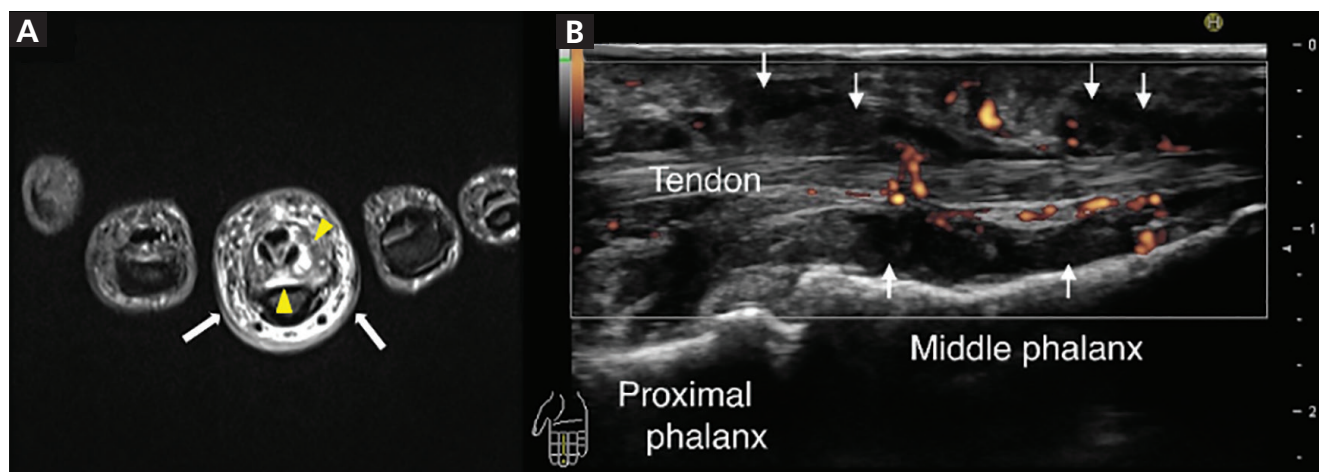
(A) Axial magnetic resonance imaging set on short time inversion recovery showed a high signal around the digital flexor tendon of the right middle finger (yellow arrowheads) and in the subcutaneous tissue (white arrows). (B) Ultrasonography of the right middle finger (sagittal view) showed a low echoic area (white arrows) and power Doppler signals around the digital flexor tendon.
